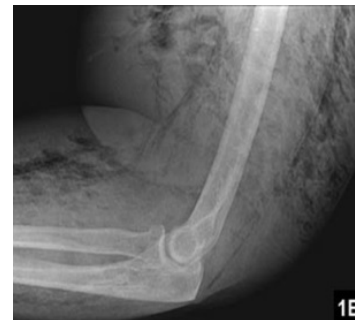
Plain X-ray film of the forearm showing inflammatory reaction and gases.
